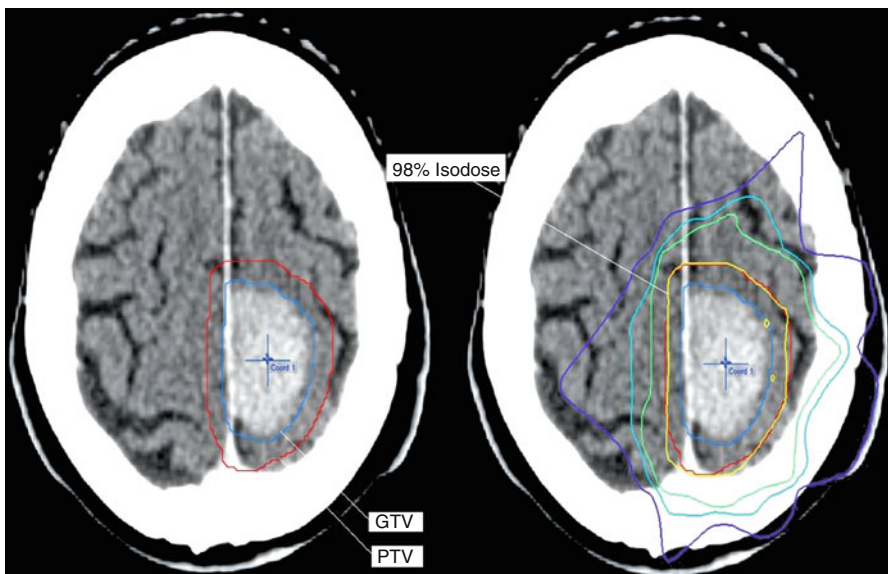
Parasagittal meningioma with dural attachment and isodose lines on axial CT views
